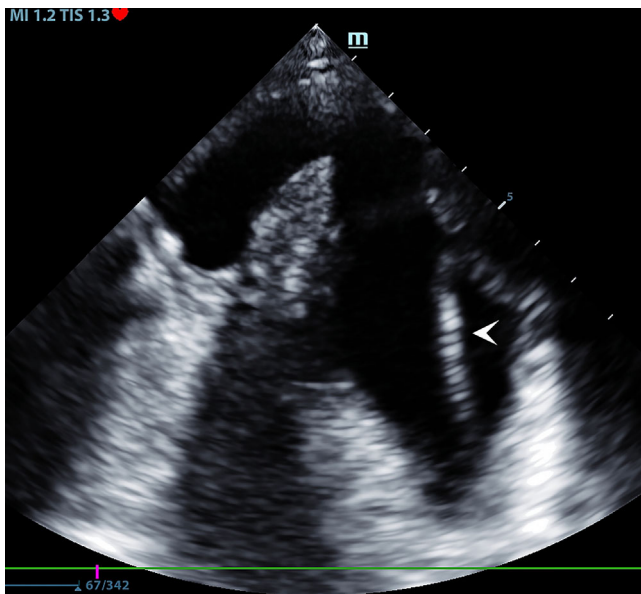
Transthoracic echocardiography showing a hyperechoic linear structure in the lumen of the descending aorta (arrowhead), suprasternal view
